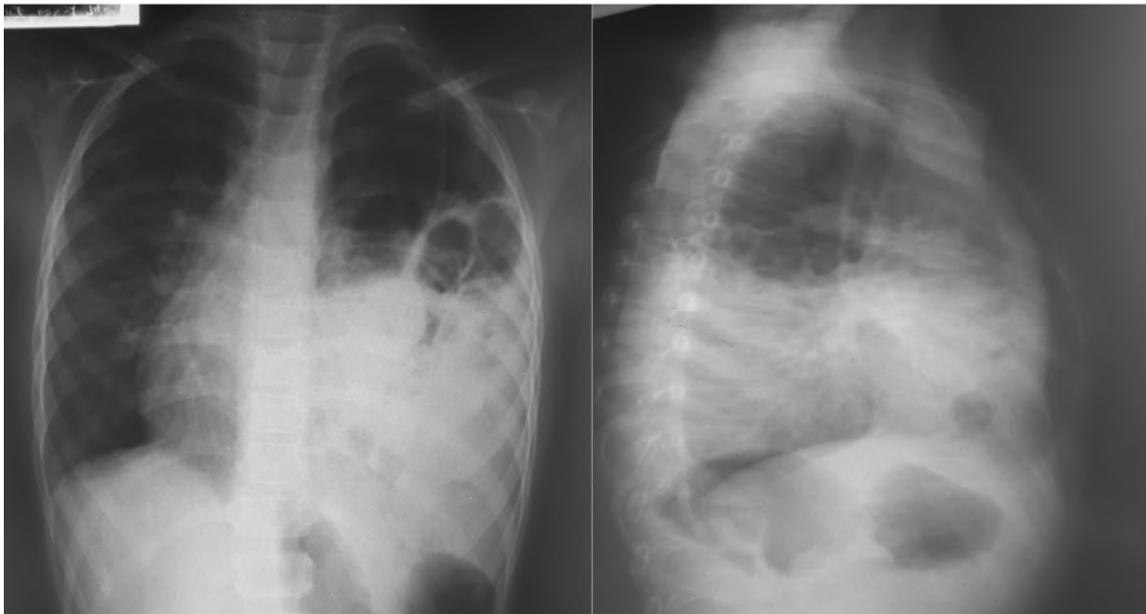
Chest radiograph of the 6 year old patient showing bowel loops in the left hemithorax.
